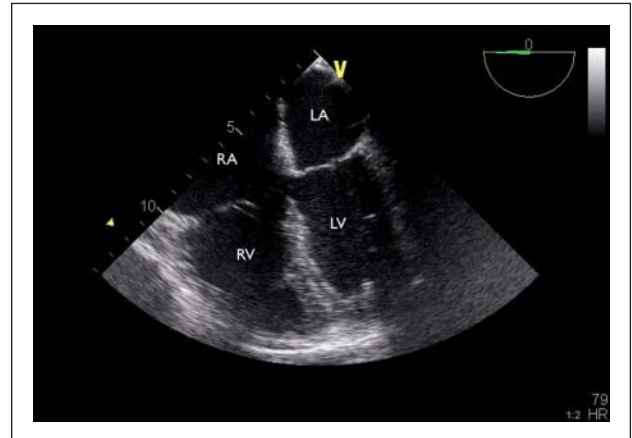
RV failure from mid-esophageal 4-chamber transesophageal echocardiography image. RV/LV size >1 . A hypokinetic RV free wall with sparing (residual contractility) of the RV apex is suggestive of acute cor pulmonale, which is suggestive of pulmonary embolism in the appropriate clinical context.
